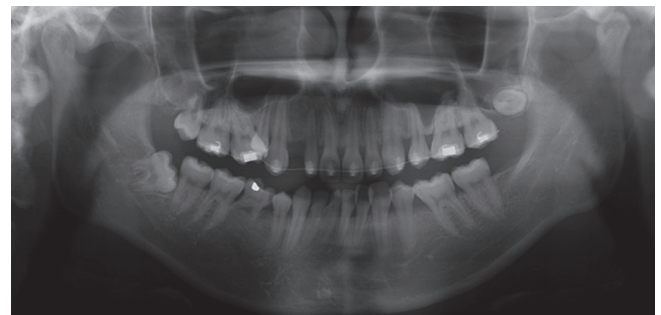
Panoramic radiographic view at initial visit shows a congenitally missing right mandibular 2nd premolar, dental caries of the right mandibular 2nd primary molar, and a sound right maxillary 3rd molar.
